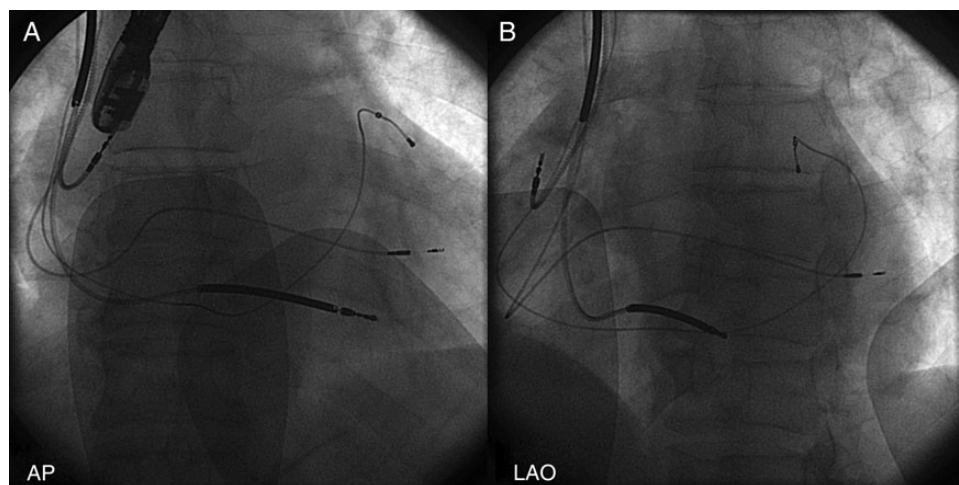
X-rays in the anteroposterior and left anterior oblique view of the implant. The left ventricular endocardial pacing lead was located at the basal lateral site, different from the previous left ventricular coronary sinus lead.
